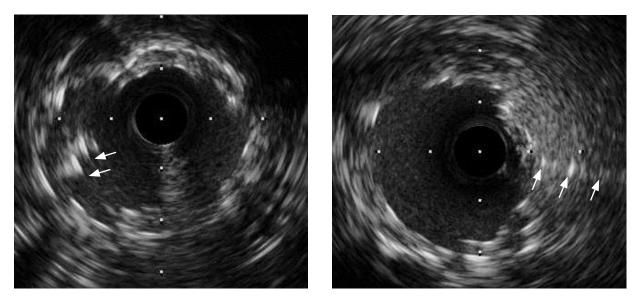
Intravascular ultrasound of the left coronary artery. A) Stent malapposition (arrows) is visible in the LMCA. B) After balloon dilation of the LMCA, linear metal material (arrows) is visible; this likely represents the broken stent string at the middle of the LMCA.
